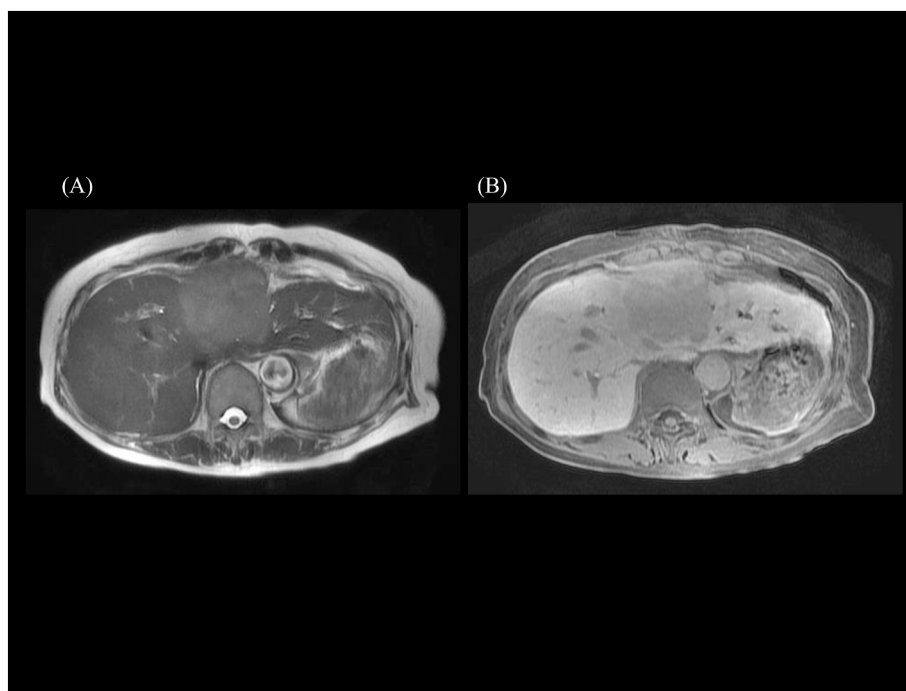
MRI. A: T2-weighted MRI demonstrated a slightly high-signal intensity on the liver mass. B: EOB-MRI showed low-signal intensity.
